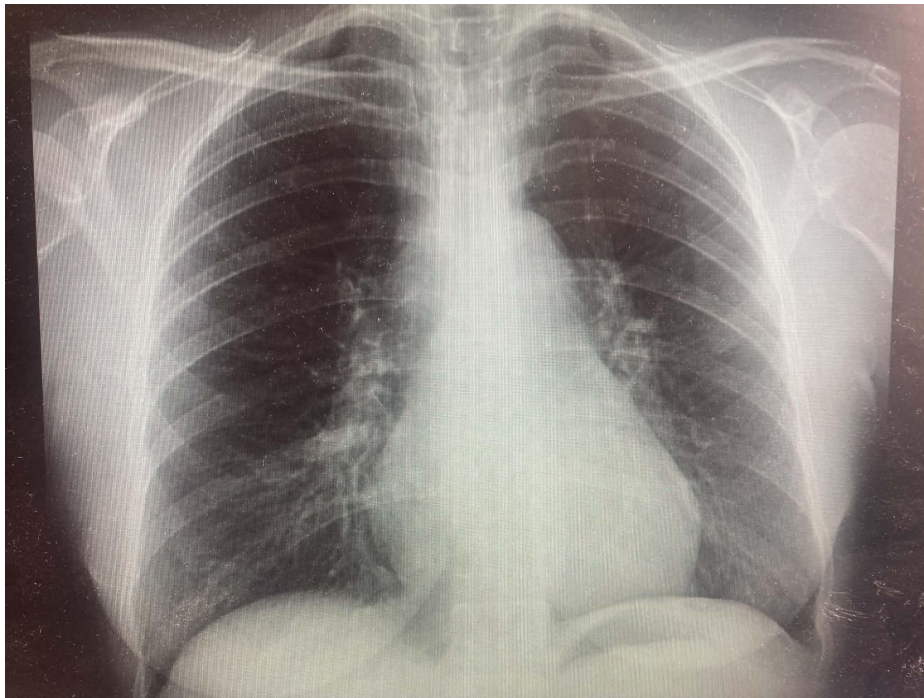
Chest-X-ray of the patient showing stage 1 sarcoidosis.
